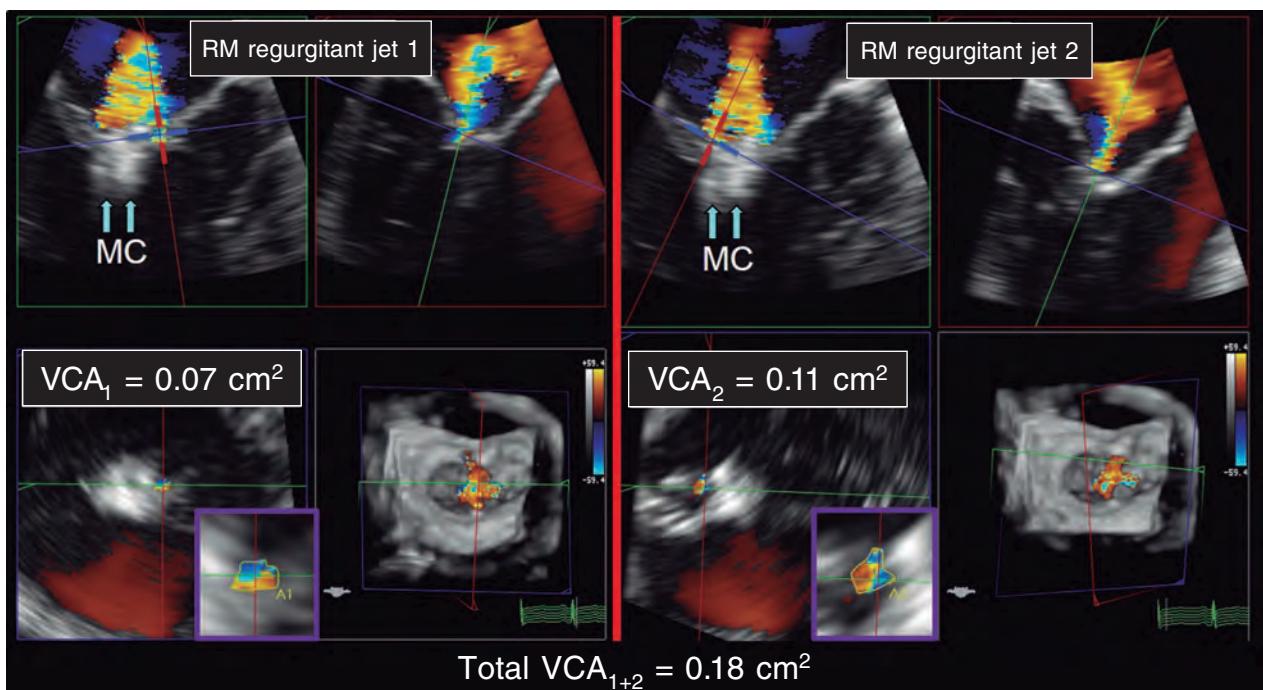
Two- and three-dimensional transesophageal echocardiography images. A: first mitral regurgitation jet (MR jet 1) after clip implantation (arrows, MC). B: second mitral regurgitation jet (MR jet 2) after clip implantation (arrows, MC). C: 3D-guided vena contracta area (VCA₁) estimate of the first jet with a result of 0.07 cm^2 . D: 3D-guided vena contracta area (VCA₂) estimate of the second jet with a result of 0.11 cm^2 . The sum of the 3D-guided vena contracta areas (total VCA₁₊₂) is 0.18cm^2 . MC, MitraClip; MR, mitral regurgitation. VCA, vena contracta area. Reproduced with permission from Avenatti et al.¹³.
